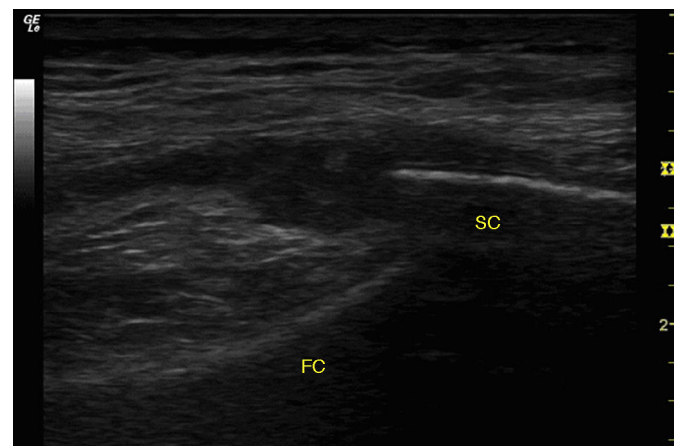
Ultrasound of right knee. Longitudinal view of the external parapatellar recess showing marked synovial proliferation of homogeneous aspect. FC, femoral cortex immediately adjacent to the lateral femoral condyle; SC, superficial cortex of the lateral patellar border.
